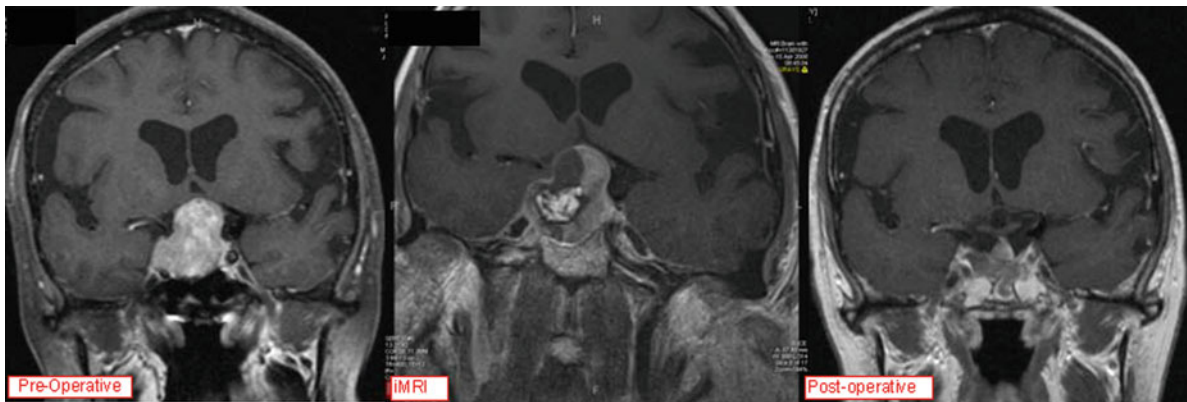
Sample pituitary adenoma case. (a) Preoperative MRI (*left*) of large non-functioning pituitary macro-adenoma with suprasellar extension. (b) ioMRI (*middle*) demonstrated evidence of residual tumor on the left side which prompted further resection of tumor. There is evidence of the autologous adipose graft in the right aspect of the sella. (c) Postoperative MRI (*right*) demonstrating resection of the residual tumor identified on the ioMRI
